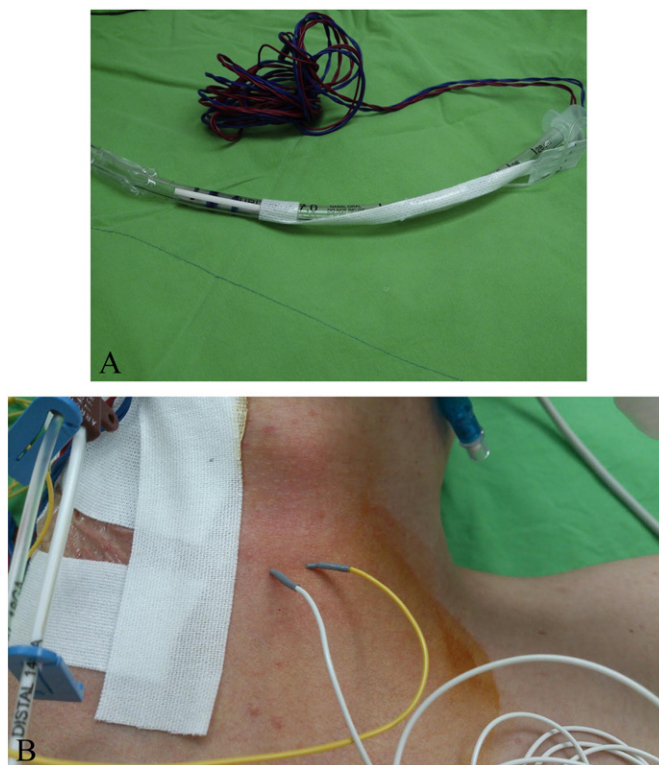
Surface recording electrodes attached to the endotracheal tube was used to record muscle activity of the vocal muscles for vagal nerve mapping (A), and monitoring (B) a pair of subdermal needles was placed in the right CT muscle under ultrasound guidance.
